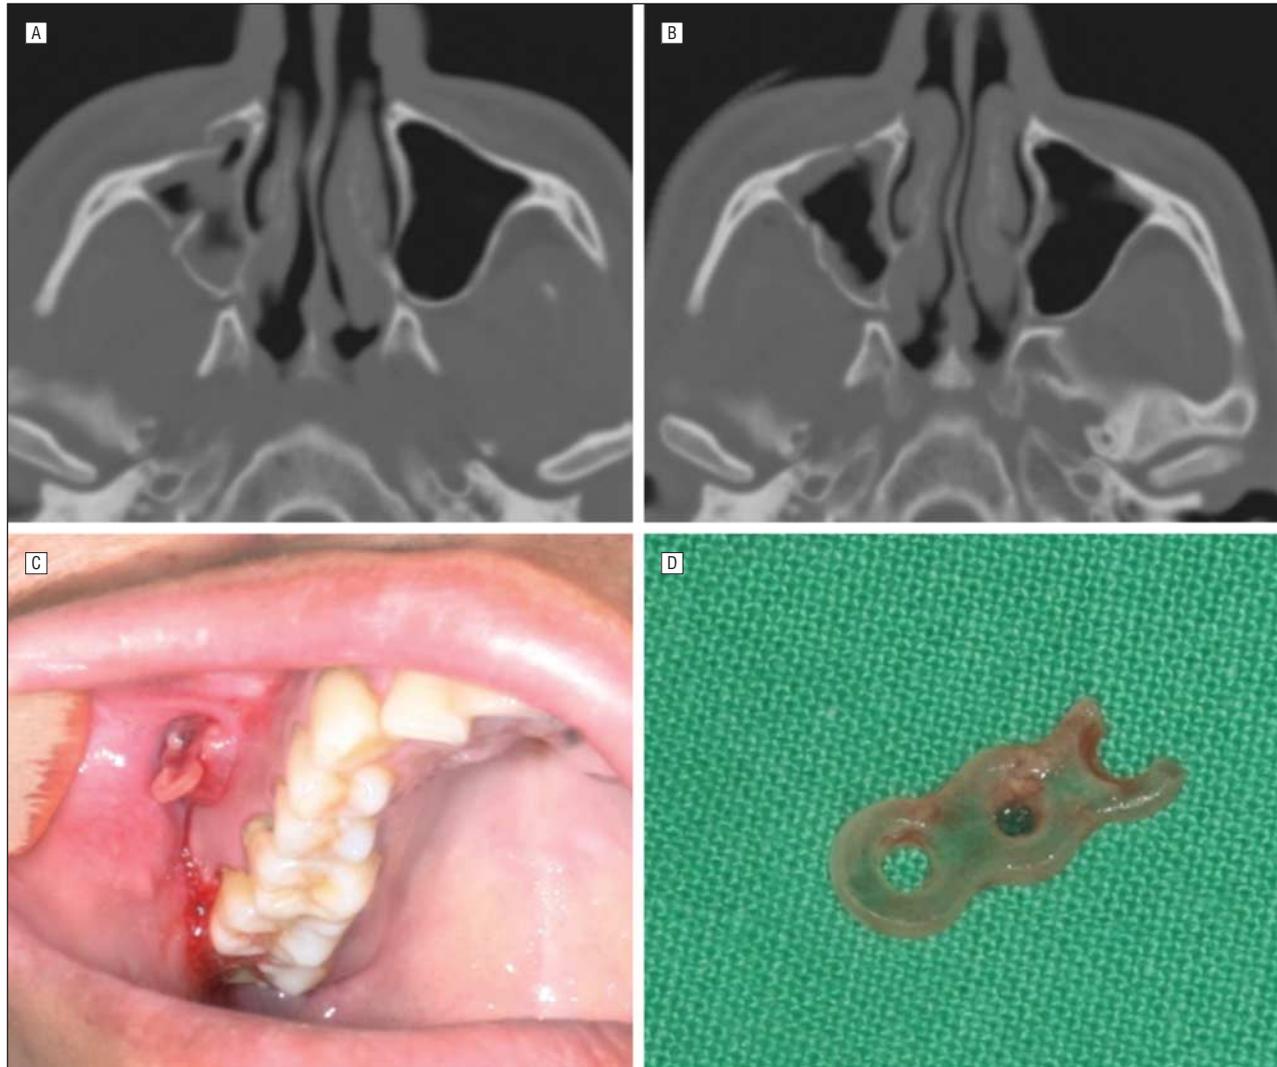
A 19-year-old patient with device exposure 12 months after surgery. Computed tomography shows fracture and displacement of the right maxilla preoperatively (A) and good alignment of the bony fragment after reduction postoperatively (B). C, The resorbable plate was exposed 12 months after surgery. D, A removed fragment of the resorbable plate.
